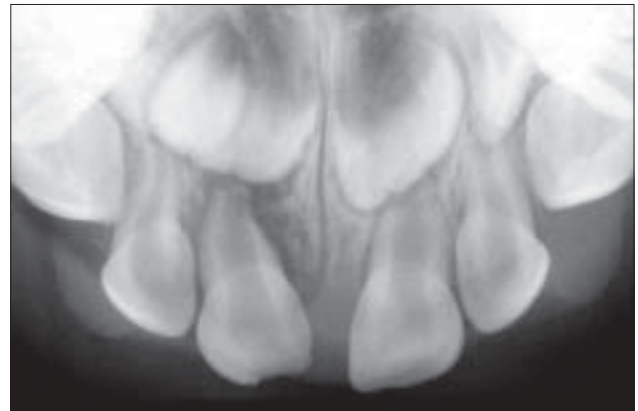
Periapical radiograph evidencing external root resorption, bone loss around the root of the necrotic tooth, and possible involvement of the permanent tooth follicle. The tooth was extracted.
